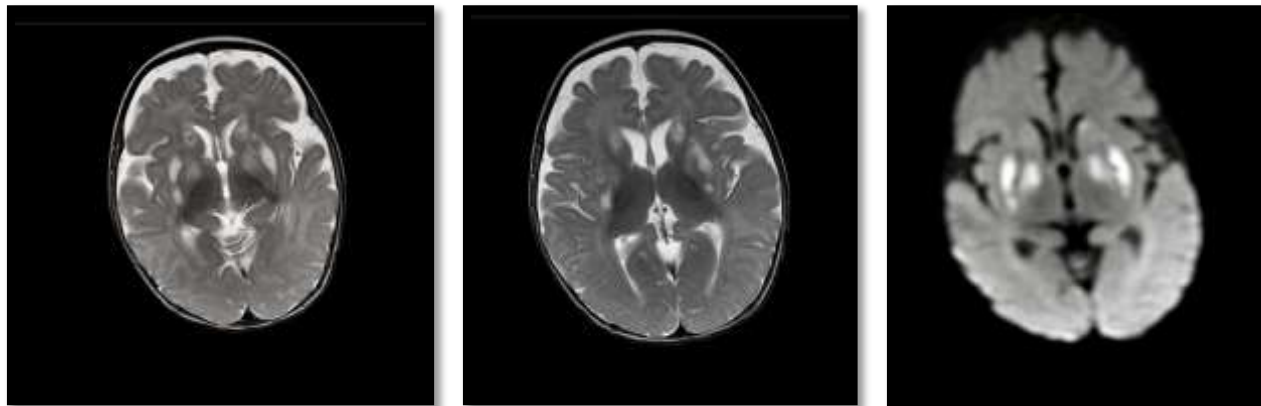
Hyperintensity in the caudate nuclei and bilateral putamen in T2 sequence of axial slice of CMR. b. Hyperintensity in the caudate nuclei, putamen and bilateral globus pallidus in T2 sequence of axial CMR slice. c. Diffusion restriction in bilateral basal ganglia region in DWI sequence.
